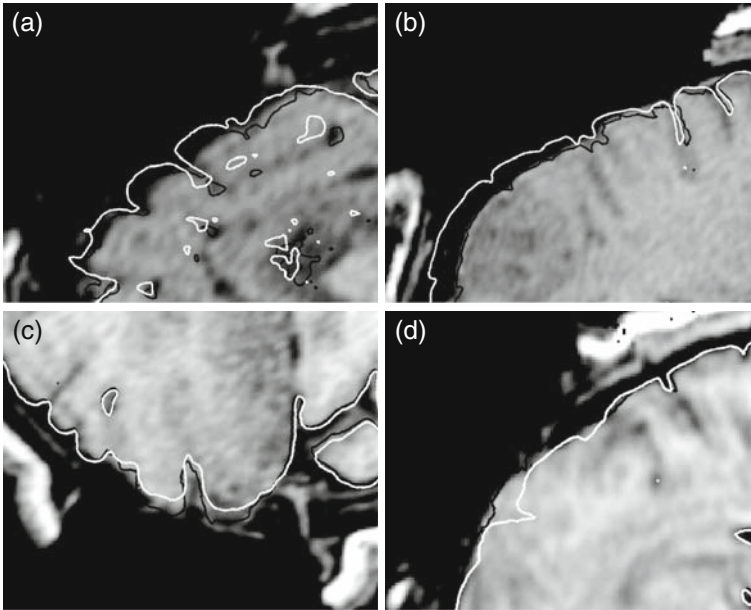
Computed deformations of the brain surface using biomechanical models for four craniotomy-induced displacements cases. The preoperative brain surface (*white*) and the computed intraoperative brain surface (*black*) are superimposed on the intraoperative MRI
